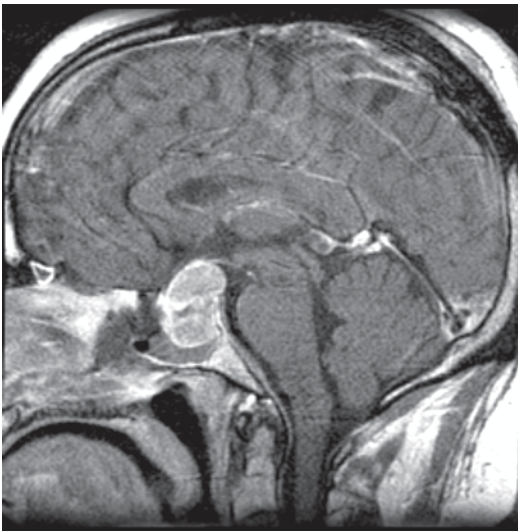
Sagittal, T1-weighted MRI with gadolinium showing a pituitary macroadenoma extending upward and displacing optic chiasm. (Courtesy of Dr. Blaine Hart)
